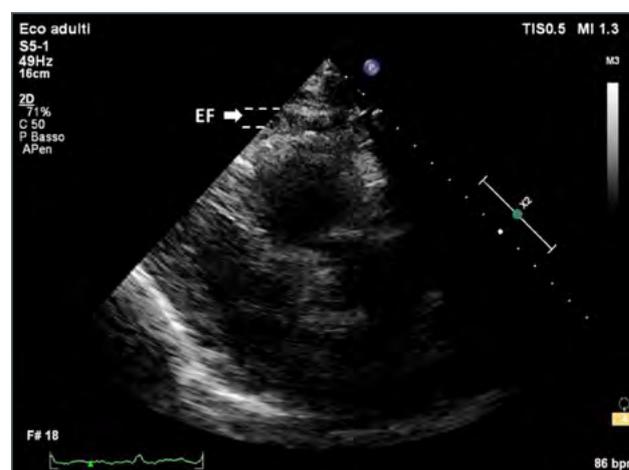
Transthoracic echocardiographic measurement of epicardial adipose tissue (white arrow), that appears as an echo-free space. EF: epicardial fat.
